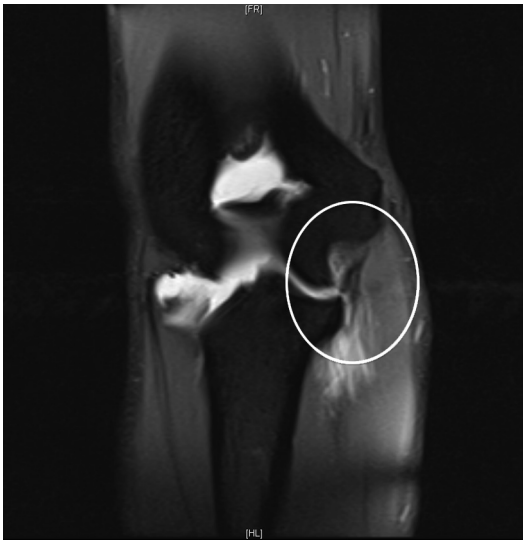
Coronal slice of an MRI demonstrating a medial UCL tear (circle).
